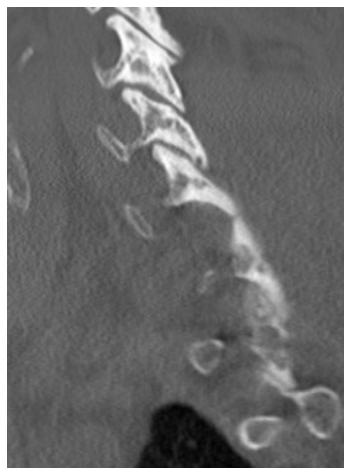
Lateral CT showing “perched facets”
